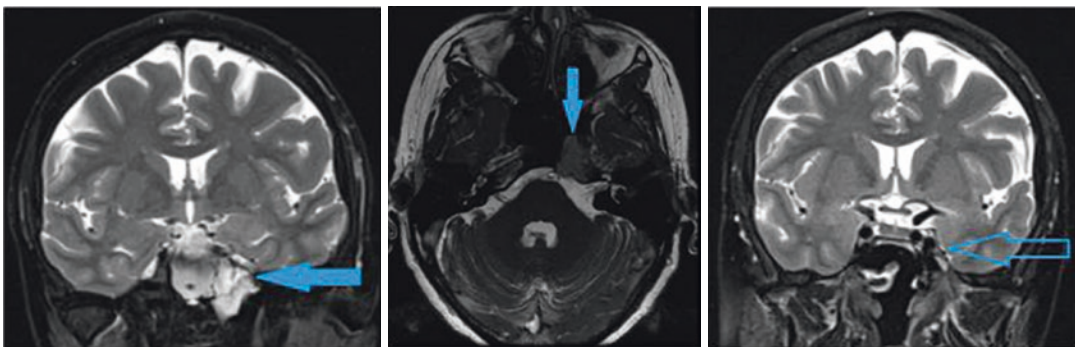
Pre-treatment MRI scan(solid blue arrow) and post-treatment MRI scan (hollow blue arrow)
